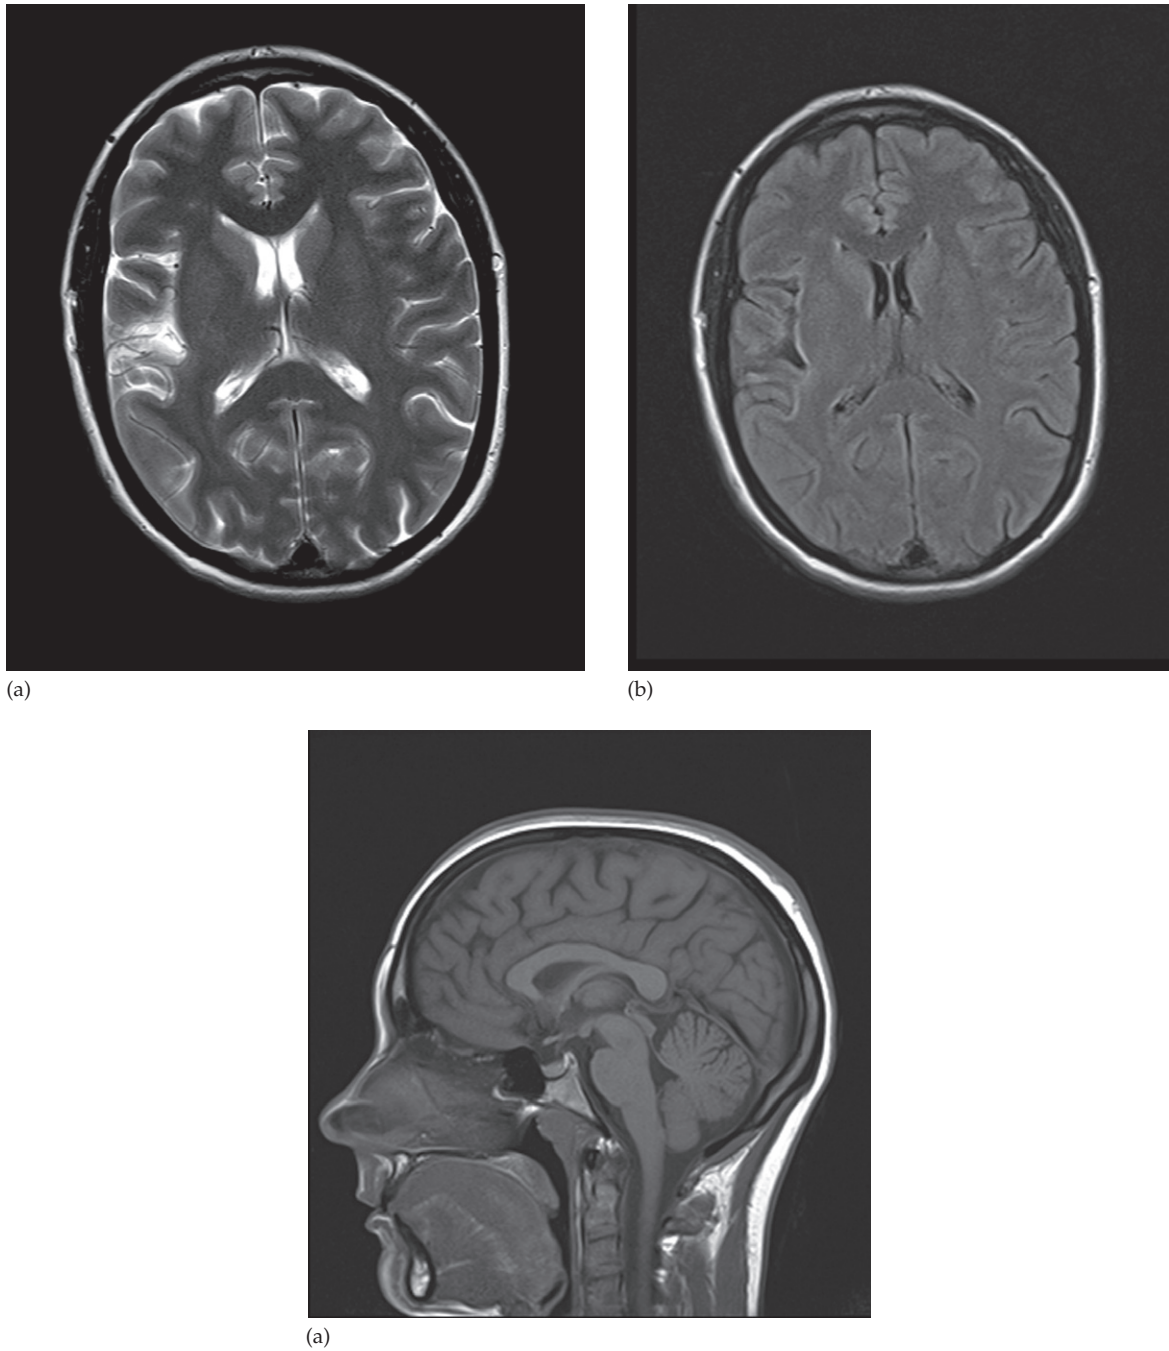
Normal brain MRI. The images are axial sections at the level of the lateral ventricles. (a) T2-weighted image. (b) FLAIR image. (c) A midline sagittal section (T1-weighted).
